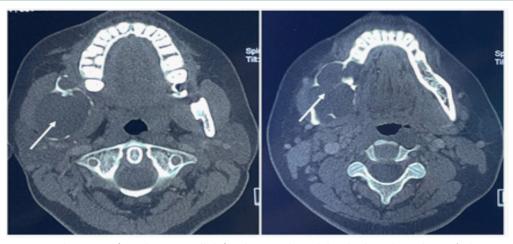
Axial section of CT showing well defined expansile multilocular hypodense lesion (White arrow) involving posterior part of mandibular alveolar arch (body), angle and ramus of right mandible with diffuse thinning and erosion of cortical margins.
